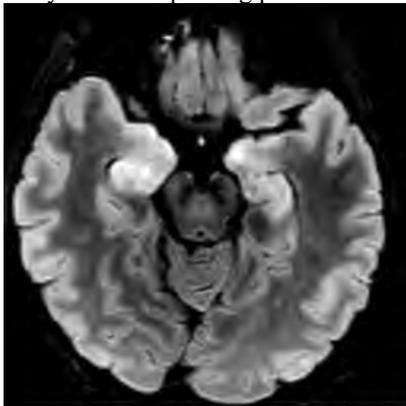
Axial T2 FLAIR image showing cortical and subcortical T2 hyperintensity in the bilateral temporal lobes in a patient with HHV6 Encephalitis.
